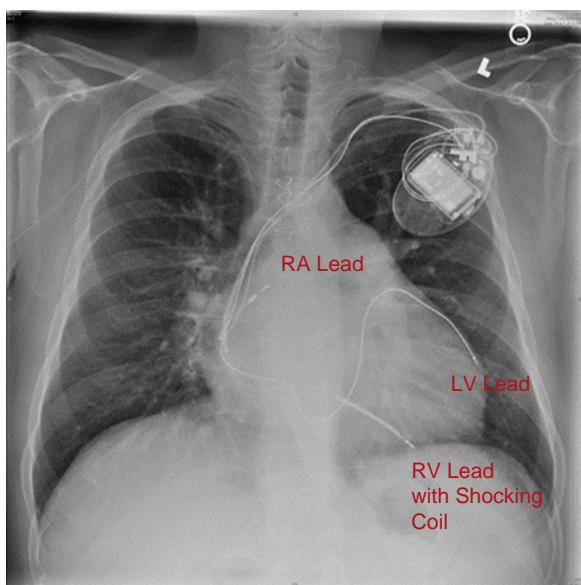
Chest radiograph: the pulse generator is located in the left deltopectoral groove. There are three leads visualized: a lead in the right atrium (RA), a lead in the left ventricle (LV) via the coronary sinus, and a lead in the right ventricle (RV). The RV lead has a thicker diameter toward the tip, indicating it is an implantable cardioverter-defibrillator lead.
